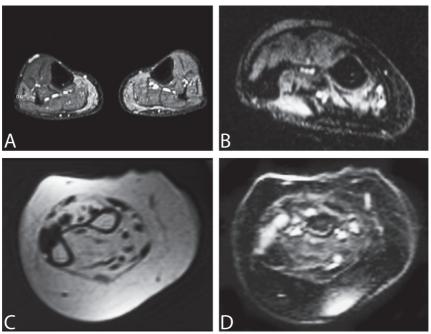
T1-weighted images with different levels of fatty infiltration in the forearm and legs Right forearm showing moderate (A) and severe (B) fatty infiltration of the FDP. Upper legs (C and D) showing severe fatty infiltration of the vastus muscles, with relative sparing of the rectus femoris muscle and hamstrings.
